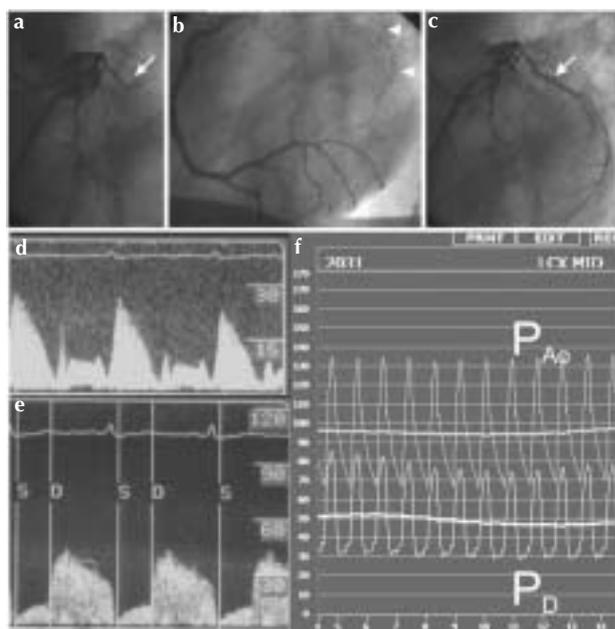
Assessment of collateral function by Doppler flow velocity and pressure recordings in a 63-year-old male patient with a proximal occlusion of the left circumflex artery (a, arrow), filled via collaterals from the right coronary artery (b, arrowheads). (c) The reopened artery. (d) Flow velocity signal distal to the occlusion. (e) Flow velocity signal in the reopened artery. The collateral signal shows predominantly systolic flow; normal flow in the artery is predominantly diastolic. (f) Recordings of aortic (P_{Ao}) and distal pressure (P_D).
